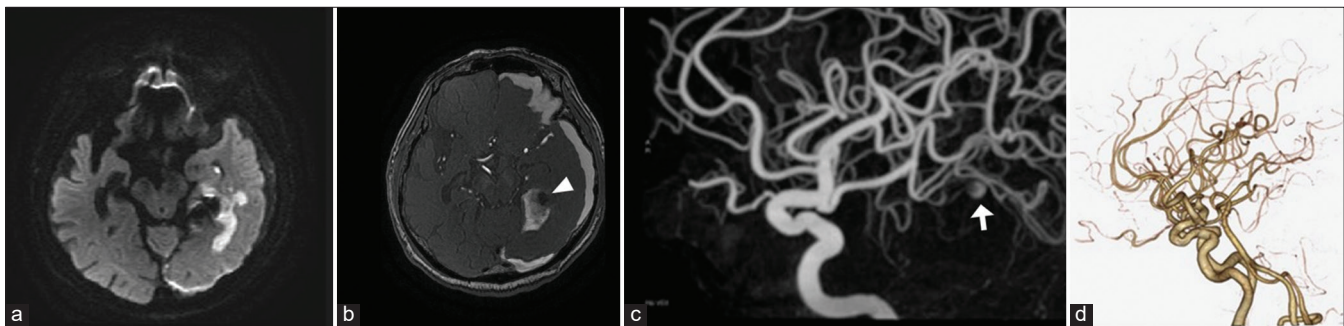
(a) Magnetic resonance (MR) imaging showing a small infarction in the temporal lobe. (b) MR angiography revealed the absence of intra-aneurysmal flow (arrowhead). (c and d) Computed tomography angiography revealed the disappearance of the aneurysm (arrow).
